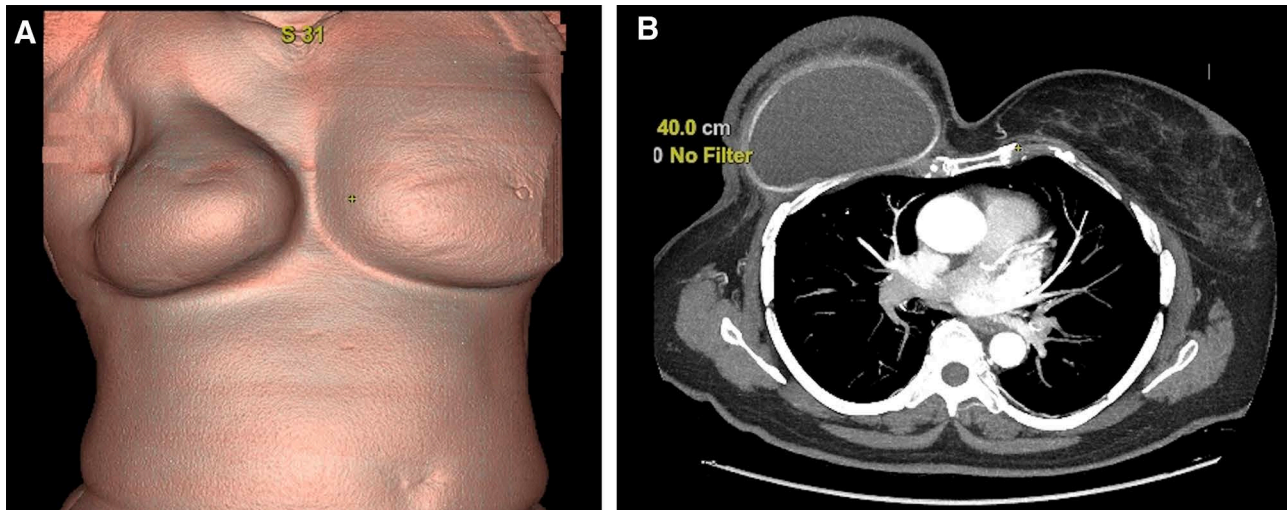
Case 1: preoperative angio-CT. A, 3D reconstruction with the skin position of the perforator. B, Cross-section of the CT scan on the fourth intercostal space with the perforator's pathway through the medial and lateral inferior poles.
